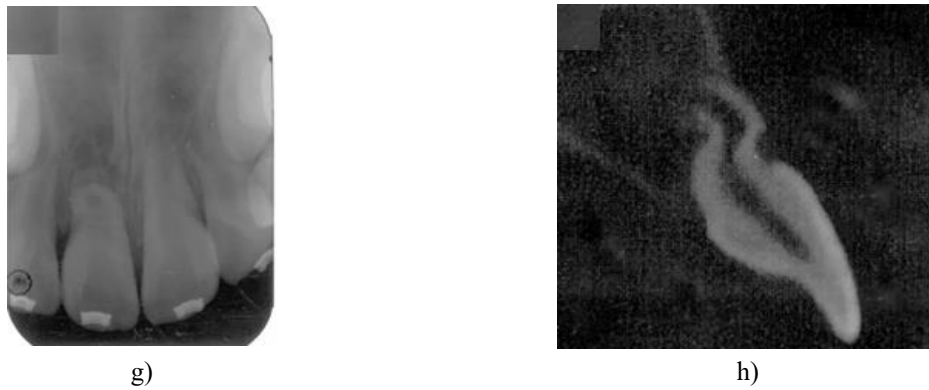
Pre-treatment intraoral and radiographic materials collected during the initial evaluation of case 3: (A) Frontal intraoral perspective, (B) Maxillary occlusal intraoral perspective, (C) Panoramic x-ray, (D) Periapical x-ray focused on the right maxillary central incisor, and (E) Sagittal computed tomography (CT) cross-section of the right maxillary central incisor.
